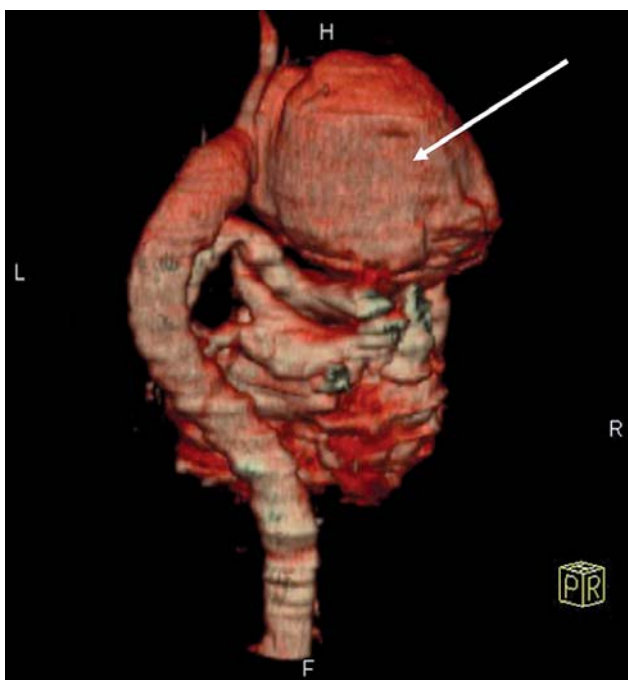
Giant aneurysm of the ascending aorta and aortic arch (CT reconstruction) in patient 2
